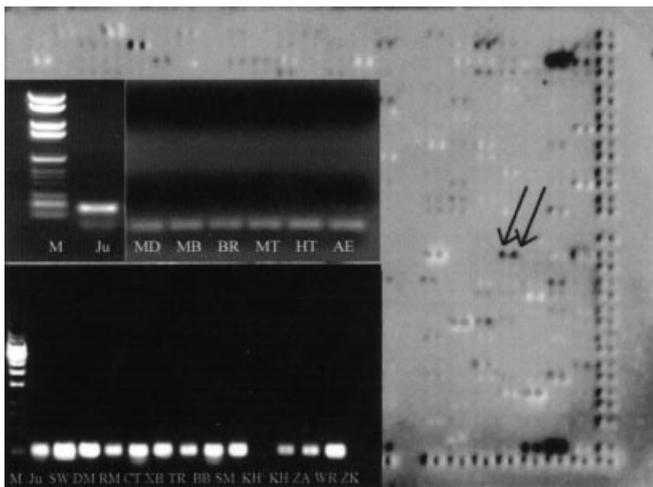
Differential expression of 588 genes in autologous PBMC and cultured CTCL cells analyzed by microarray hybridization. mRNA has been isolated from CTCL cells and healthy PBMC (both derived from patient SM) and reverse transcribed into cDNA. Then, samples have been subjected for hybridization with an array comprising 588 different genes related to human tumors. Results are presented as an overlay of two blots. Black dots indicate mRNA that is present in tumor cells only, the arrows indicate specific hybridization of CTCL mRNA with a probe coding for IFN- γ antagonist cytokine (GenBank: A25270; cytokine IK). Insert: Expression of IK mRNA in psoriasis vulgaris biopsies (MD, MB, BR), eczema biopsies (MT, HT), atopic dermatitis biopsies (AE), cell cultures or tissue samples from mycosis fungoides lesions (SW, DM, RM, TR, BB), PBMC from patients with Sézary syndrome (CT, XB, SM, KH, ZA, WR), Jurkat cells (Ju) and healthy donor PBMC (ZK). KH¹ = as a control, RNA has been isolated from sorted CD7⁺ PBMC only.
